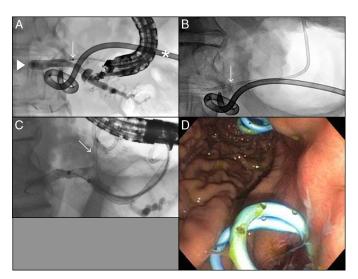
Endoscopic ultrasound-guided management of a PCF resulting from a percutaneous drain (asterisk) following pancreaticoduodenectomy in case 1. (A) Endoscopic ultrasound-guided pancreatography demonstrates a complete obstruction of the pancreaticojejunostomy (arrowhead). (B) A single plastic stent is placed draining the pancreatic duct to the stomach. (C and D) A guidewire and double pigtail stent was passed via the echoendoscope into pancreatic duct, then back into stomach via the original transgastric tract (arrows). The shafts of the stents traverse the pancreatic duct.
